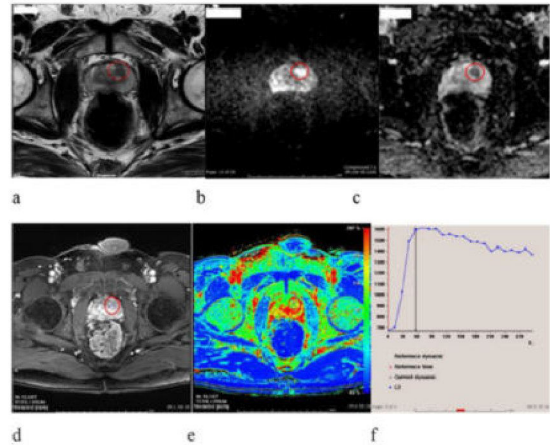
Example of prostate MRI evaluation of an Axial T2WI with a 0.8-cm circumscribed lesion located in the left anterior aspect of TZ at midglnd level (marked with a circle); b, c corresponding apparent diffusion coefficient (ADC) map showing a reduced signal and diffusion-weighted imaging (DWI) on high b value (1,500 s/mm²); d, e, f related dynamic contrast enhanced (DCE)-MRI with steep initial slope of contrast media uptake followed by a quick washout (type 3 curve).
